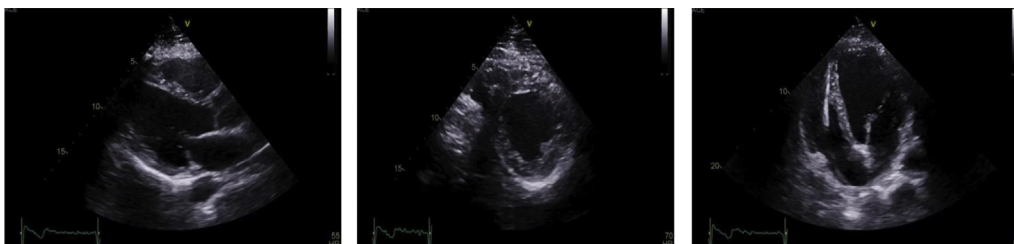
Transthoracic echocardiogram images 4 months post implantable cardioverter-defibrillator insertion. Parasternal long axis, parasternal short axis, and apical 4-chamber views (left to right). Left ventricle mildly dilated and left ventricular ejection fraction 40%.
